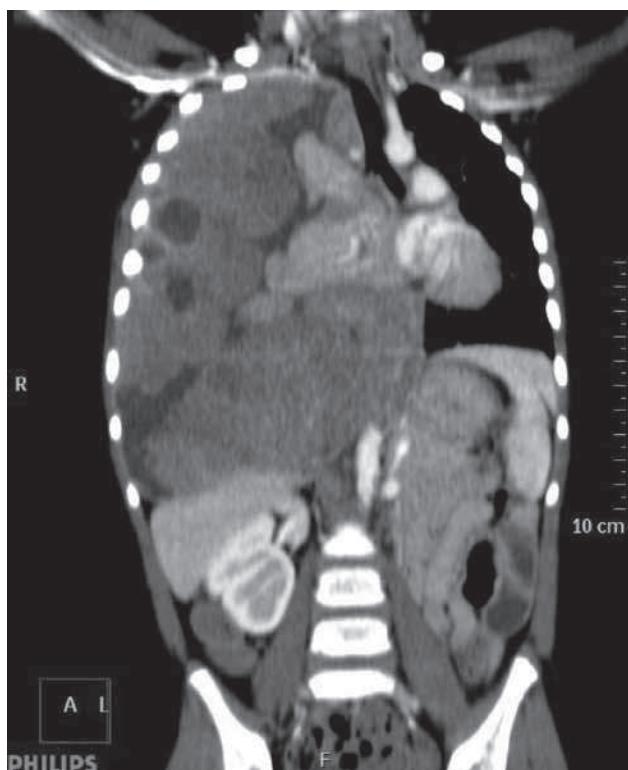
Chest CECT (contrast enhanced computed tomography): Coronal view that presents the huge mass occupying right hemithorax, causing hemidiaphragm inversion and displacing downwards the liver. The mass shows contrast enhancement; of note, its internal hypodense necrotic areas.
